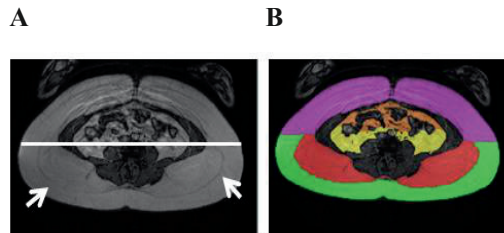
MRI of the subdivision of abdominal adipose tissue depot. On the trans-axial planes, abdominal SAT depots were divided into anterior and posterior regions as previously described [A, B] (He, Engelson, & Kotler, 2005; Ross et al., 2002) and the visceral adipose region was further divided into the intraperitoneal (brown) and extraperitoneal (yellow) regions with specific anatomical reference (Abate et al., 1994; Abate et al., 1997) [B]; the white arrows [A] indicate the Scapa's fascia separating the abdominal subcutaneous adipose tissue into deep (red) and superficial (green), and anterior regions (purple) [B].
